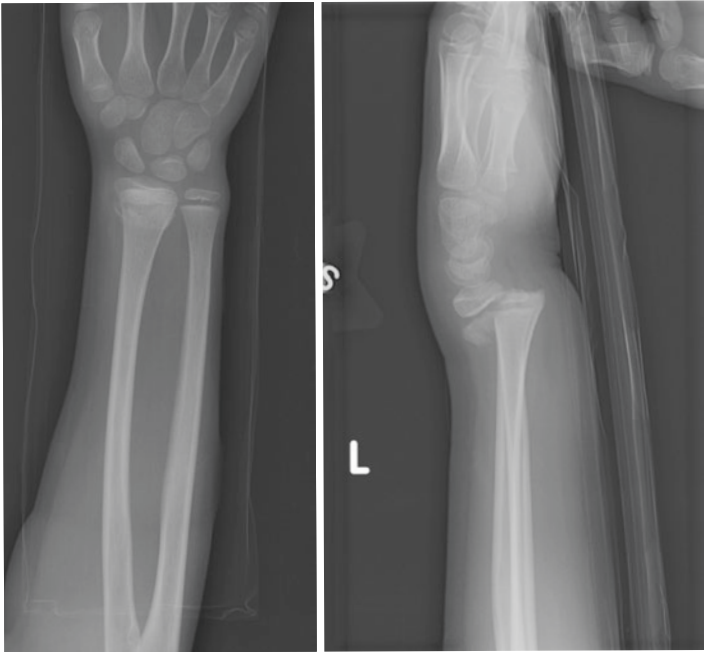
AP and lateral radiographs of a Salter-Harris II physeal fracture in a skeletally immature patient
